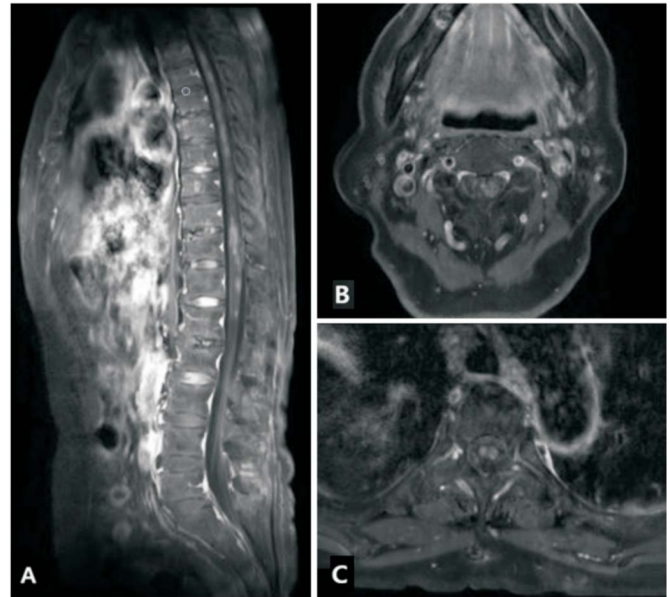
Whole spine magnetic resonance imaging and T1-weighted gadolinium-enhanced images. (A) The sagittal view shows longitudinal high-signal intensity along the spinal cord throughout the thoracic spinal cord. Axial views of (B) cervical cord and (C) thoracic cord show hyper-signal lesions predominant at the center of the cord with peripheral enhancement.
